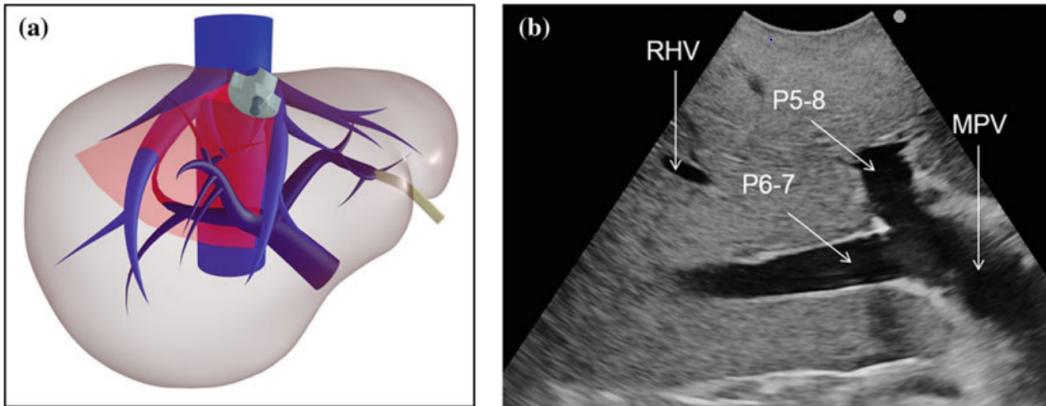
Left (a) ultrasound image plane in the liver. Right (b) intraoperative ultrasound image. One can see the right hepatic vein (RHV), the portal branch to segments 5 and 8 (P5-8) and the portal branch to segments 6 and 7 (P6-7) [38]
